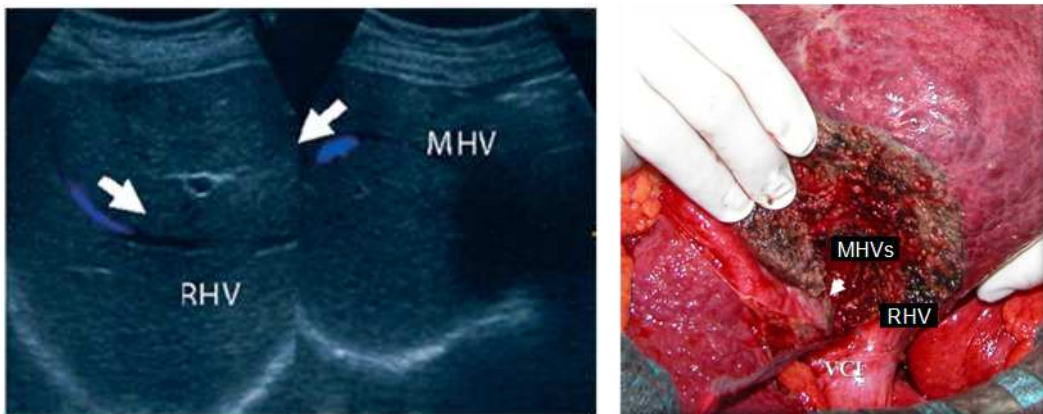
Intraoperative ultrasound at the same patient: the Doppler intraoperative examination describes the collateral circulation between the right hepatic vein (RHV) and the medial hepatic vein (MHV) after the ultrasound guided compression of the MHV; the flow in the distal portion of the MHV is inverted (hepatopet). Intraoperative aspect postresection at the same patient: the stump of the medial hepatic vein (MHVs) can be seen on the transe. RHV – right hepatic vein.
